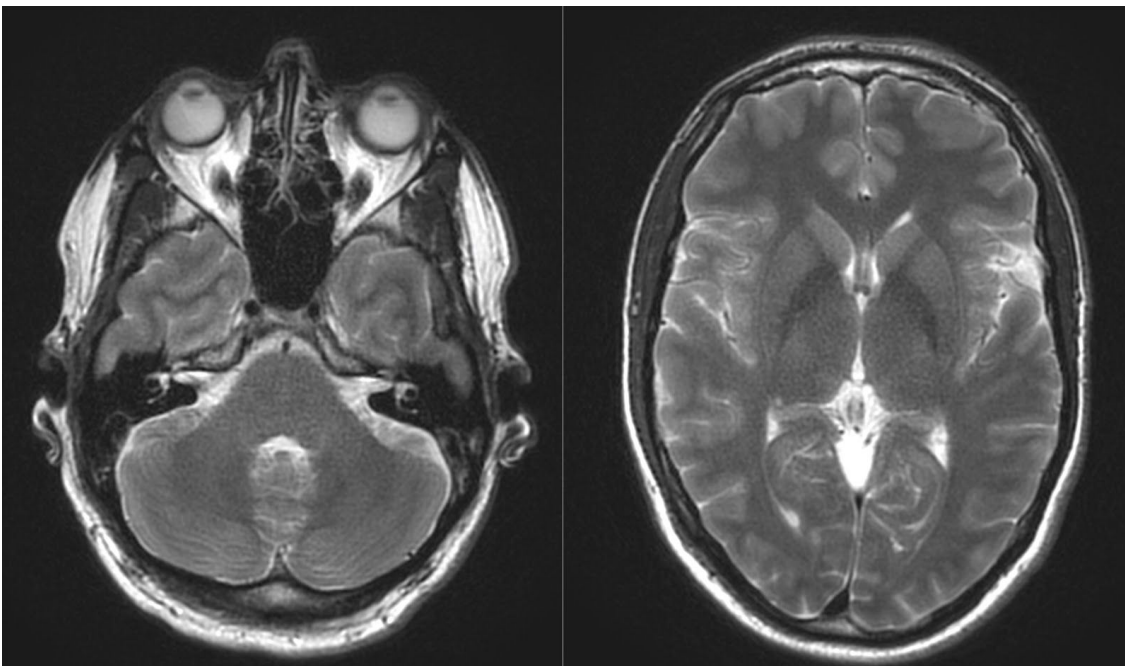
Two slices of an SMS and in-plane accelerated T2-weighted PROPELLER, with an acquisition time of 32 seconds.*
